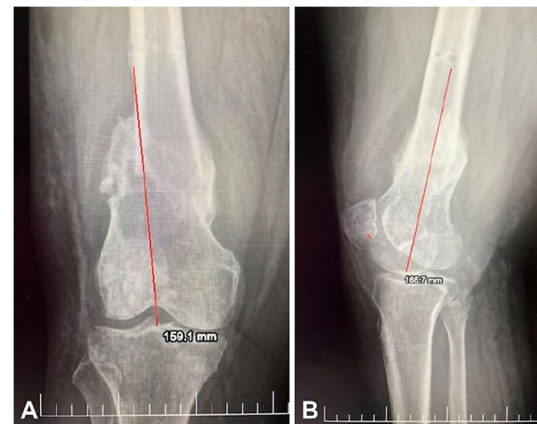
(A and B) Right femur X-rays (three months after the spontaneous fracture), after external fixator removal showed fracture consolidation.
